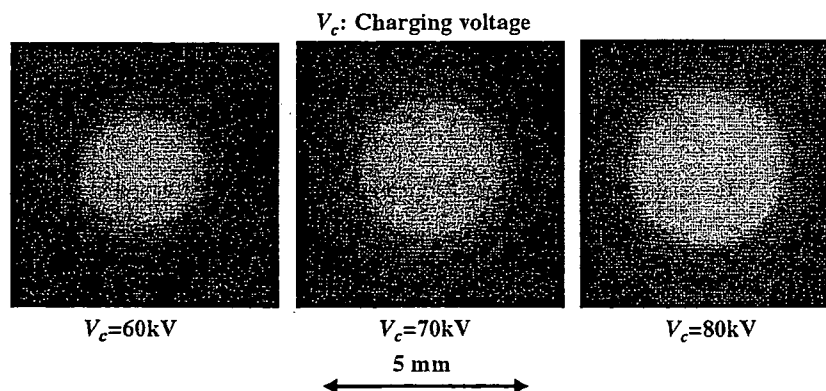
Images of characteristic X-ray source obtained using a pinhole camera with changes in the charging voltage.
